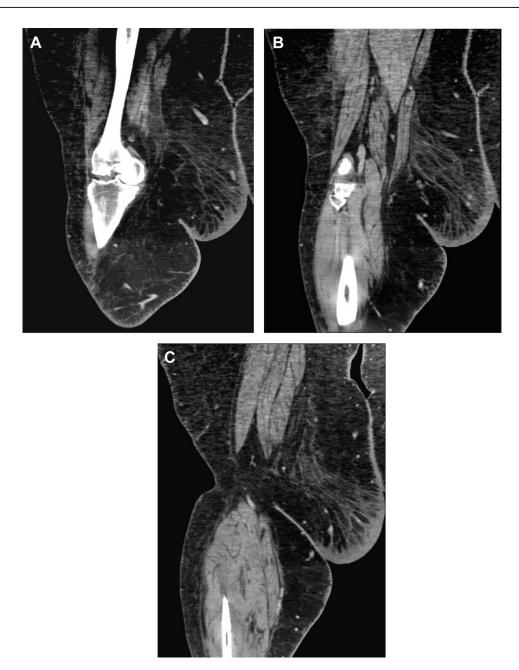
A 46-year-old woman with redness and swelling of the medial right thigh—CT. Coronal contrast-enhanced CT images from anterior to posterior (A-C) demonstrate a mass-like pendulous fatty-appearing lesion with skin thickening and striated soft-tissue edema.
